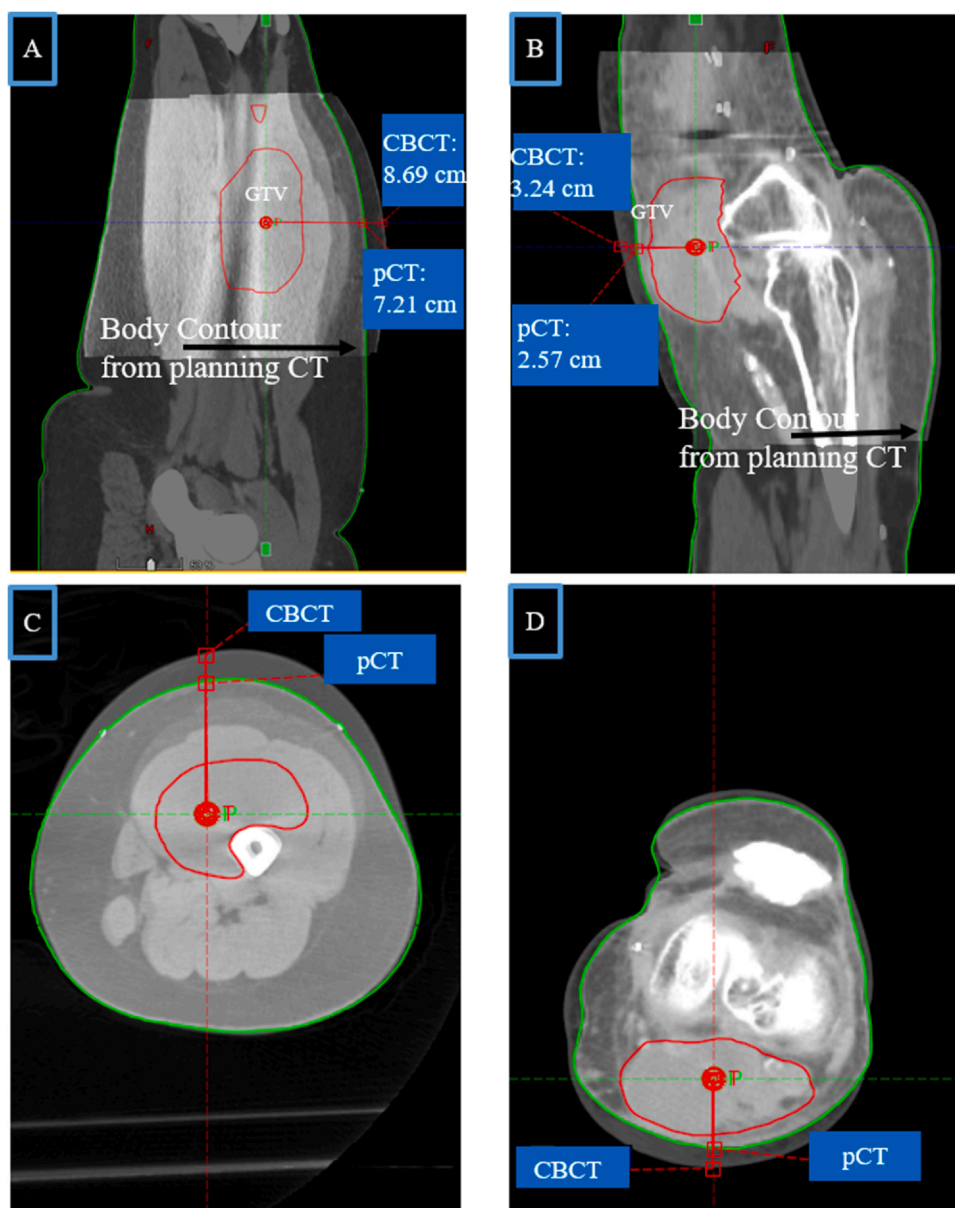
Overlaid planning CT (pCT) and cone-beam CT (CBCT) images of sagittal (A) and axial (C) planes in a patient replanned at fraction 20 due to changes in anatomy; and sagittal (B) and axial (D) planes in a patient replanned at fraction 13 due to swelling. The red contour is the gross tumor volume (GTV), and the green contour is the patient body. These images are solely for demonstration purpose. The BPL change is acquired automatically using the home-grown software.
